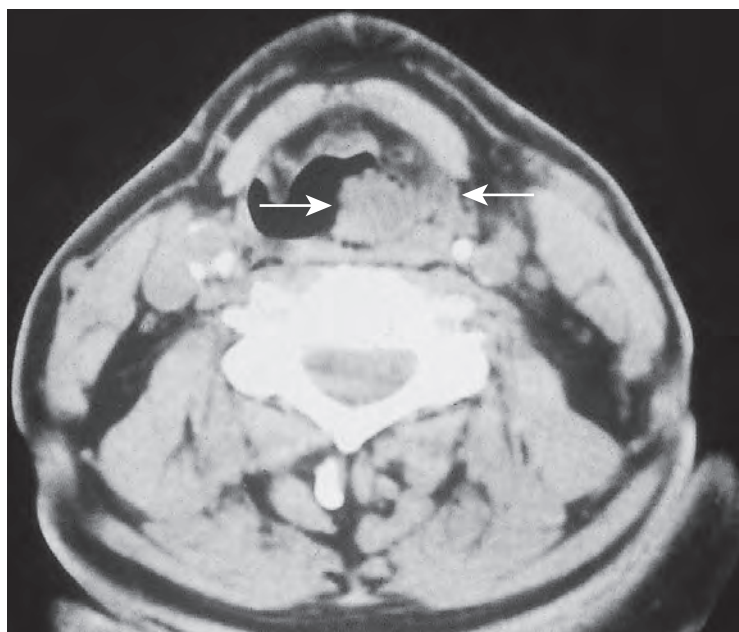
CT scan in the axial view showing a chondrosarcoma of the cricoid cartilage encroaching upon the airway.
